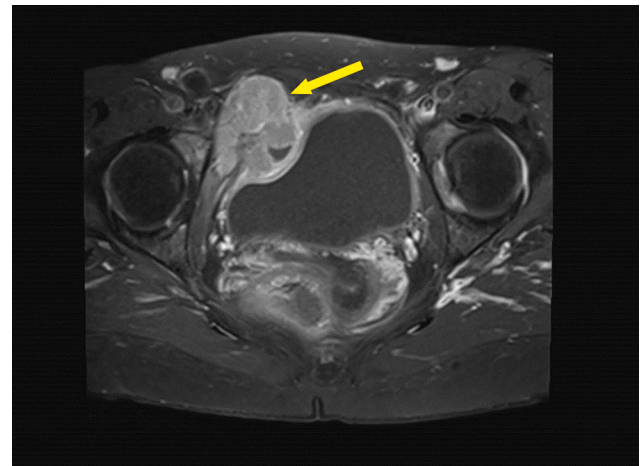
MRI demonstrating a tumour in the right iliac fossa.
